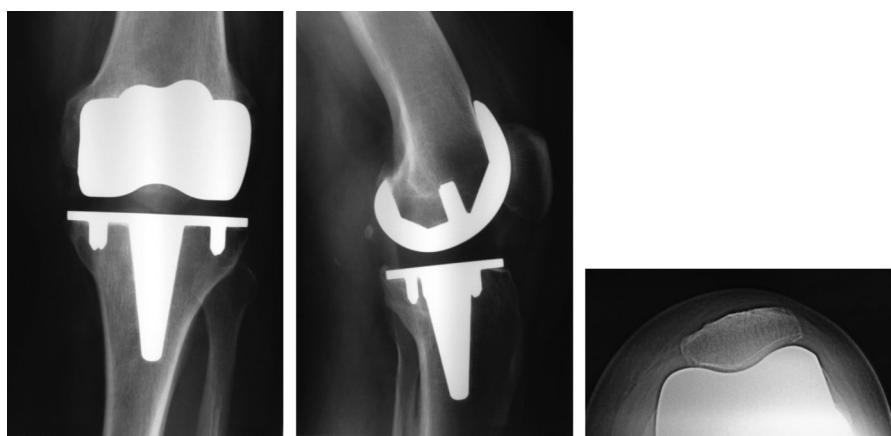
Radiograph of mobile bearing implant after 10 years.
